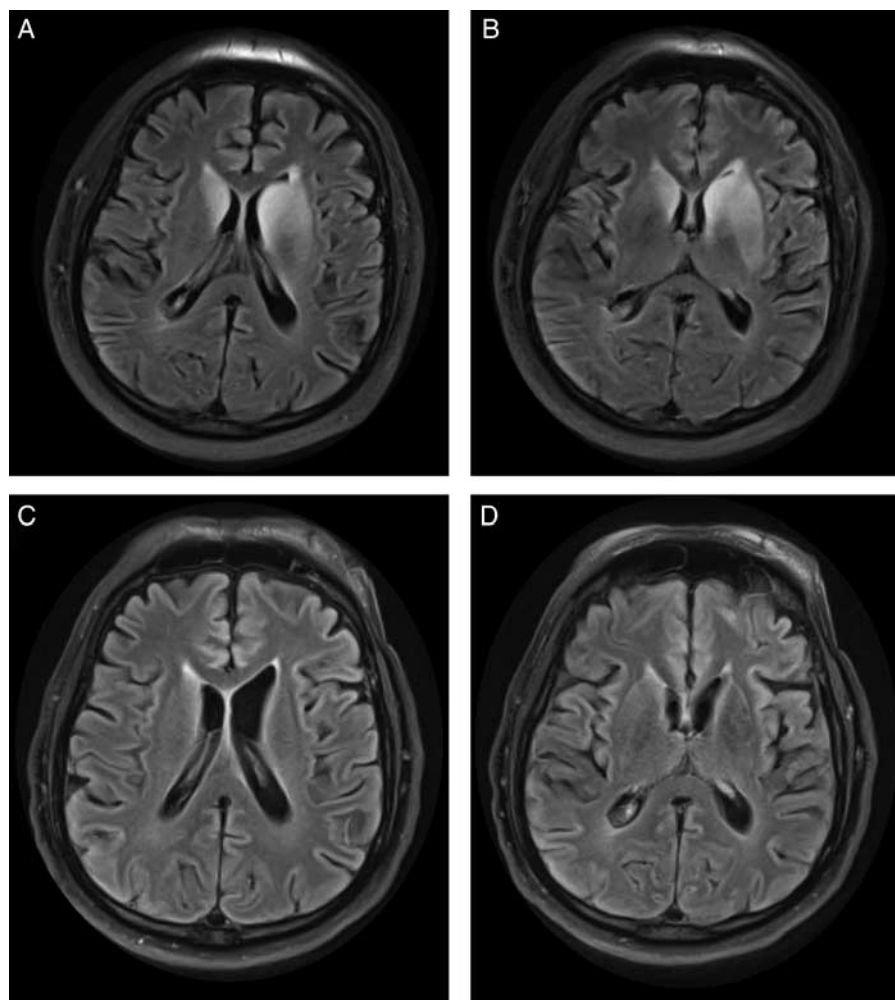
Brain magnetic resonance imaging at presentation (A, B), and after treatment with intensive immunotherapy (C, D). A, B, T2-FLAIR hyperintensities were evident in the left caudate, putamen and globus pallidus, and right caudate. There were no areas of contrast enhancement or diffusion restriction (not shown). C, D, T2-FLAIR hyperintensities markedly improved after treatment. Repeat imaging 3 months following presentation showed global atrophy and subtly increased T2-FLAIR intensities within the temporal lobes (not shown). Images are displayed in radiologic convention. FLAIR indicates fluid-attenuated inversion recovery.
